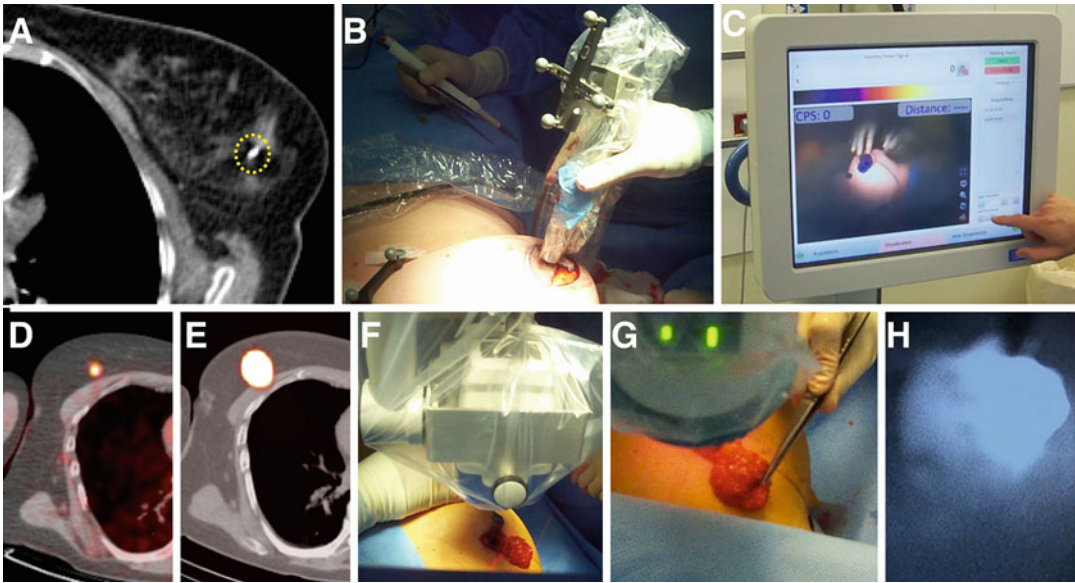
Transaxial CT (a) showing an implanted ^{125}I -seed in the *left* breast of a patient scheduled for neoadjuvant chemotherapy. Following therapy, non-palpable residual tumor containing the radioactive seed is removed using tracked freehand SPECT (b, c). In another patient an ^{18}F
